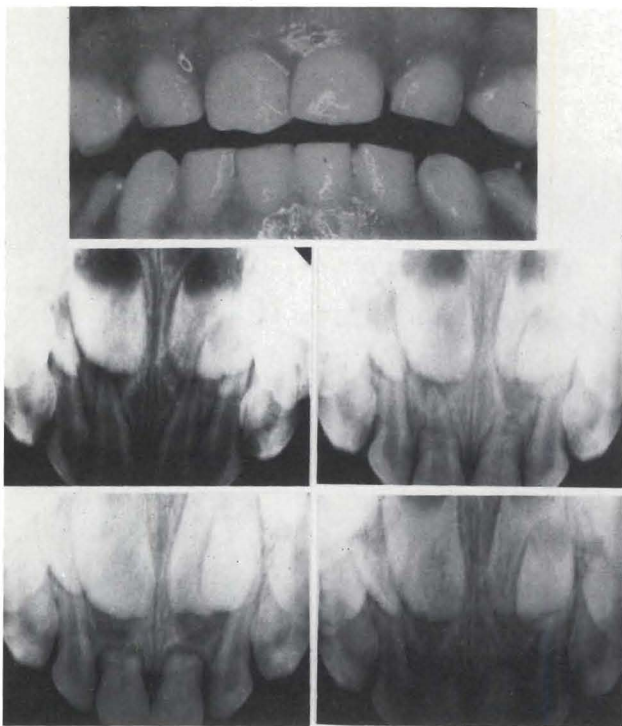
Findings: T.K., six-year, two-month-old boy struck teeth E and F; first at thirteen months. Subsequent episodes of minor trauma occurred over next five years. Teeth E and F were mobile, yellowed, not sensitive to percussion or palpation, with no soft tissue changes (clinical photograph). Radiographically, both teeth showed increased PDL space, pulp space calcification, apical external root resorption, and periapical radiolucencies. The teeth were extracted five years, one month, after initial trauma.
